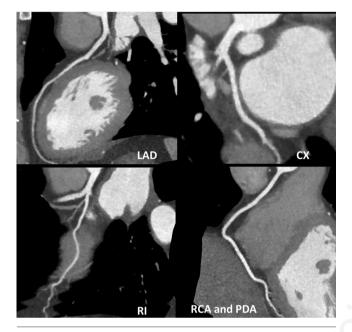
Coronary computed tomography angiography. Absence of atherosclerotic obstructive disease of the epicardial coronary arteries. LAD: left anterior descending artery; CX: left circumflex artery; RI: ramus intermedius of the left coronary artery; RCA: right coronary artery; PDA: posterior descending artery.
